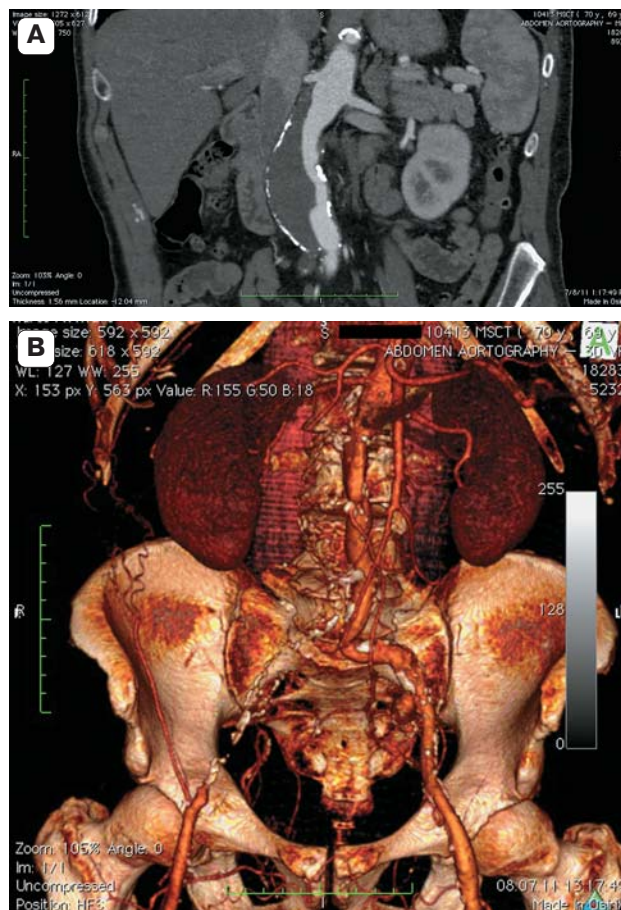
A, B. Multiplanar and 3D reconstruction of multislice CT of a patient prior to the hybrid surgical intervention.
